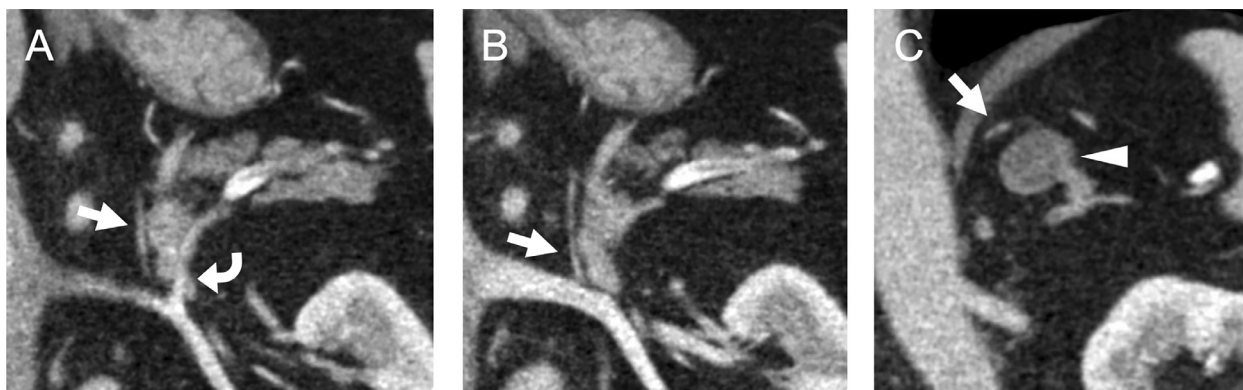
Contrast computed tomography images of the left adrenal gland in the coronal view
